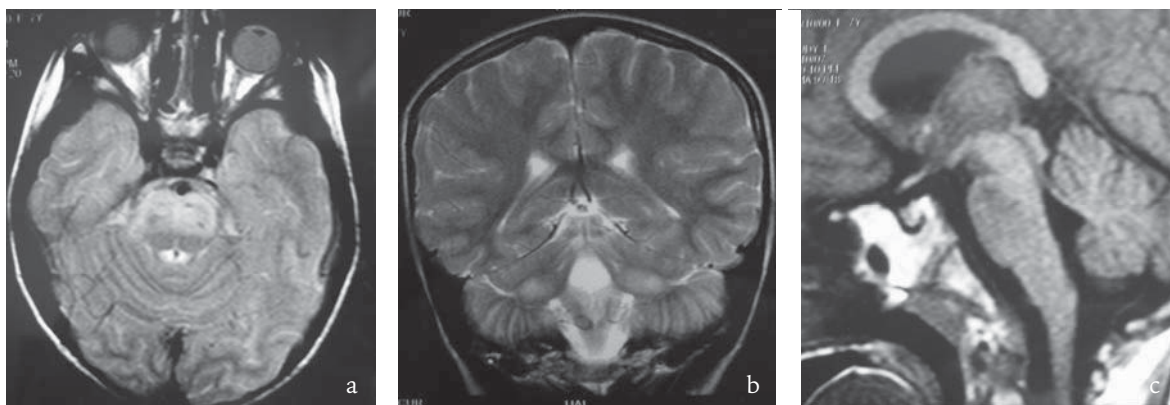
Axial (a) and coronal (b) T2-weighted magnetic resonance images in a seven-year-old boy with SSPE show hyperintense lesions in the pons (a) and middle cerebellar peduncles (b). Sagittal T1-weighted image shows hypointense lesion in the pons (c).
